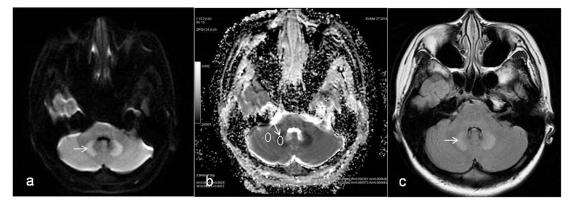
Initial MRI performed on 3T system shows high signal intensity on diffusion-weighted imaging (a), reduced apparent diffusion coefficient (b) and high signal intensity on FLAIR (c) within the dentate nuclei (arrow). Quantitative ADC measurement demonstrates a reduced ADC value of 0.44 x 10⁻³ mm²/s within the right dentate nucleus. ADC value of normal appearing ipsilateral white matter is 0.65 x 10⁻³ mm²/s.
